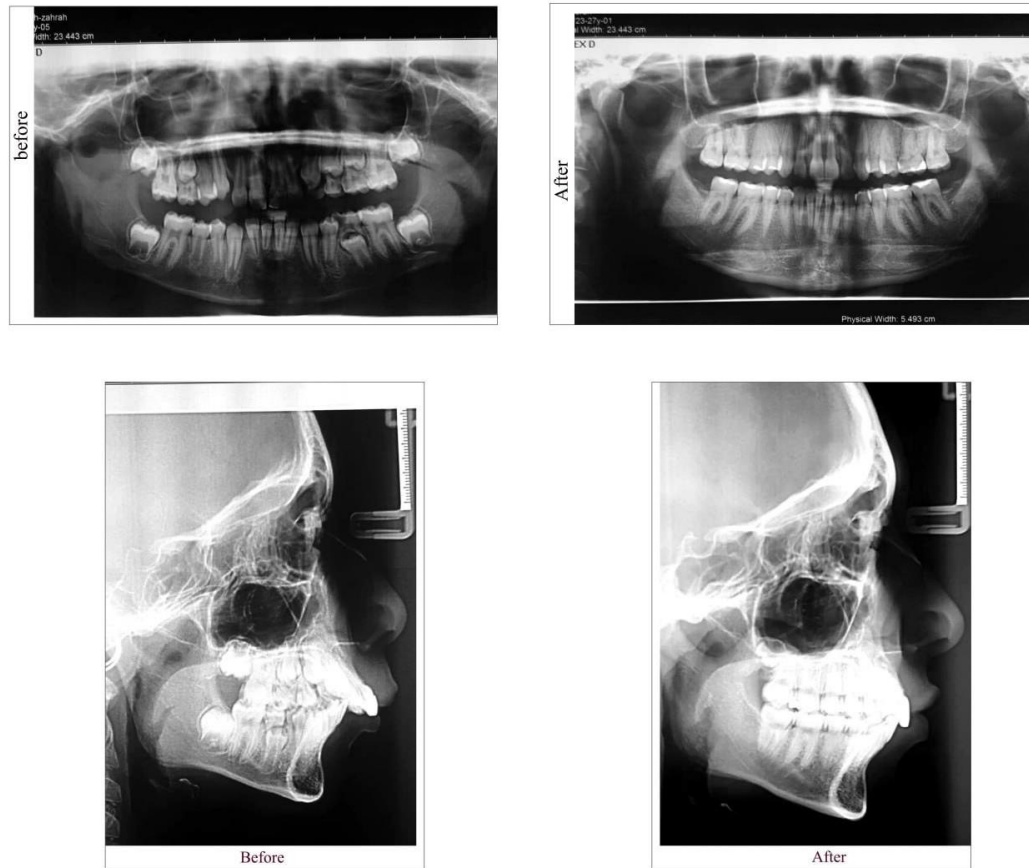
(Case I): Before and after treatment radiography in an 11 years old girl
